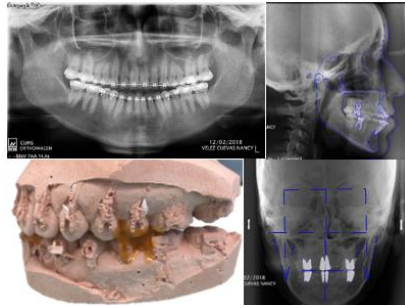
Radiographic and Pre-Surgical Model Studies
